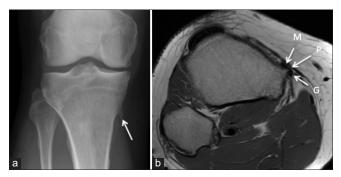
Anterior-posterior radiograph (a) and T1 axial (b) showing the pes anserine exostosis (arrow) (P) between the tibial component of the superficial medial collateral ligament (M) and gracilis (G).
